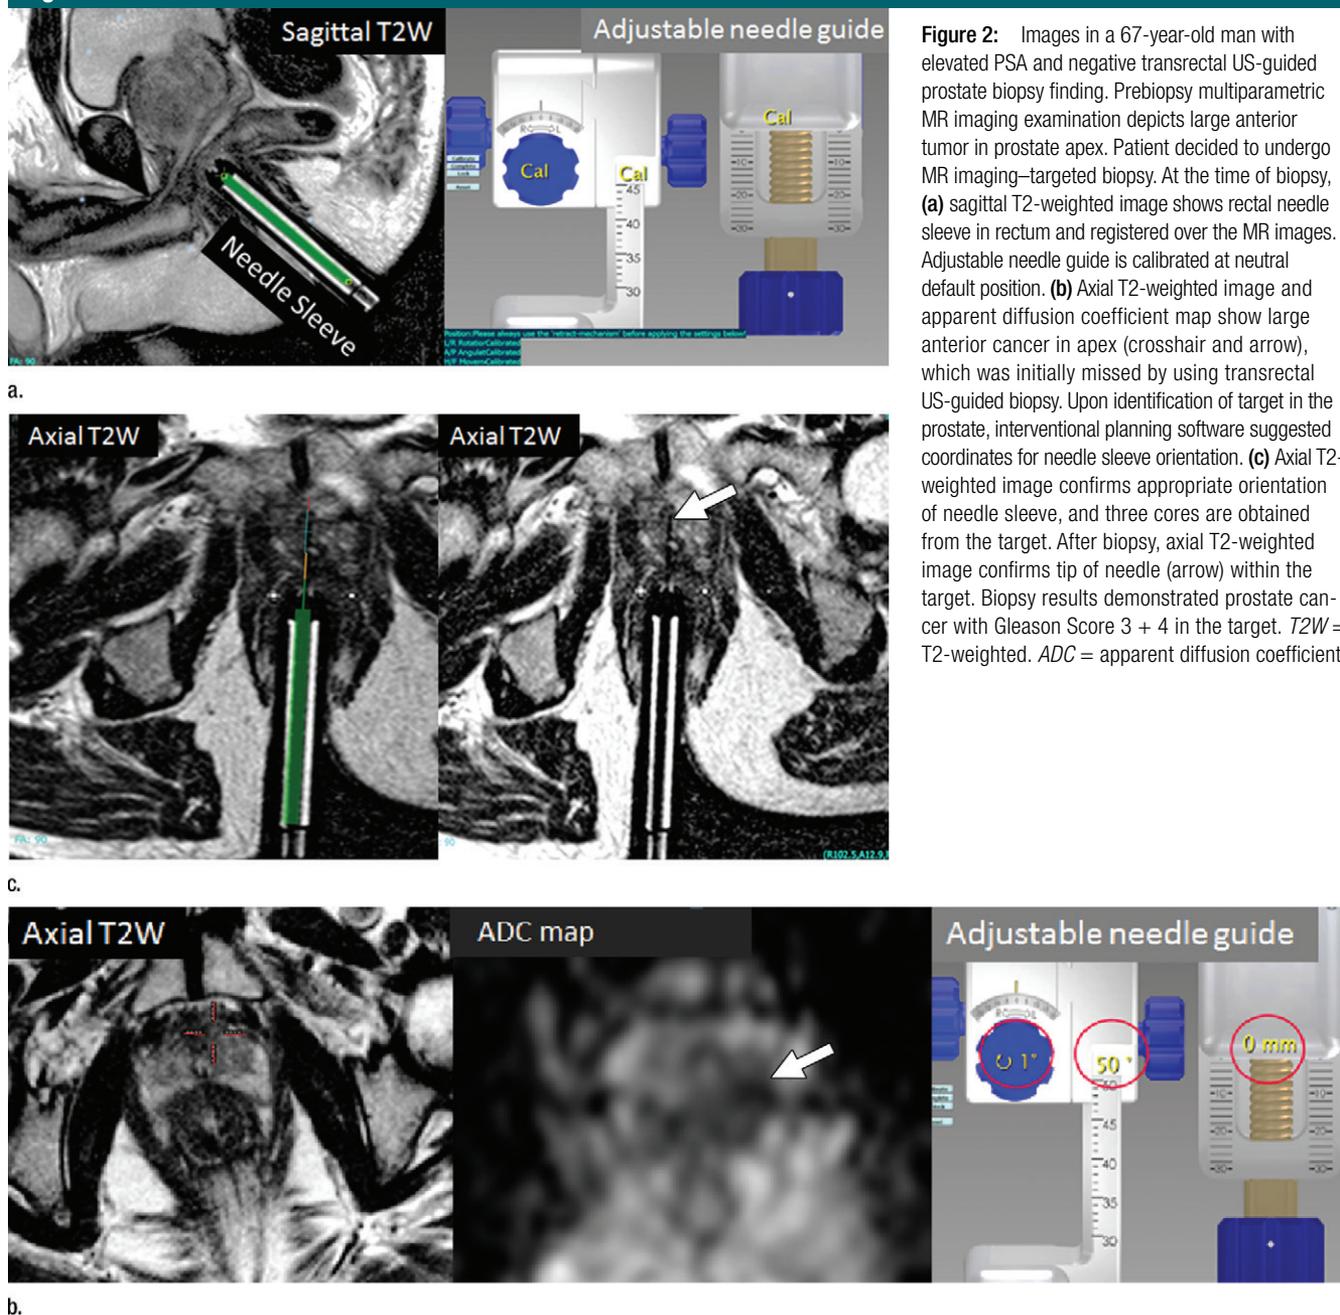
Images in a 67-year-old man with elevated PSA and negative transrectal US-guided prostate biopsy finding. Prebiopsy multiparametric MR imaging examination depicts large anterior tumor in prostate apex. Patient decided to undergo MR imaging–targeted biopsy. At the time of biopsy, (a) sagittal T2-weighted image shows rectal needle sleeve in rectum and registered over the MR images. Adjustable needle guide is calibrated at neutral default position. (b) Axial T2-weighted image and apparent diffusion coefficient map show large anterior cancer in apex (crosshair and arrow), which was initially missed by using transrectal US-guided biopsy. Upon identification of target in the prostate, interventional planning software suggested coordinates for needle sleeve orientation. (c) Axial T2-weighted image confirms appropriate orientation of needle sleeve, and three cores are obtained from the target. After biopsy, axial T2-weighted image confirms tip of needle (arrow) within the target. Biopsy results demonstrated prostate cancer with Gleason Score 3 + 4 in the target. *T2W* = T2-weighted. *ADC* = apparent diffusion coefficient.
